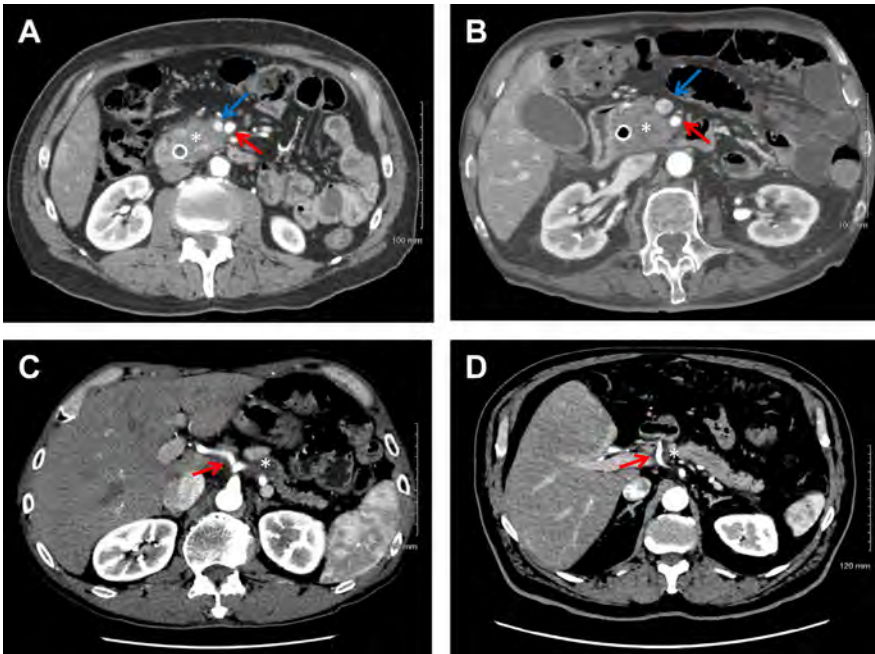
Computed tomography axial images representing borderline resectable pancreas cancer. (A) Narrowing of greater than 50% of the SMV (*blue arrow*). (B) Abutment of the SMA (*red arrow*) of less than 180°. (C) CA (*red arrow*) abutment of less than 180°. (D) Short-segment encasement of the CHA (*red arrow*) amenable to reconstruction. Tumor is marked by *asterisk*.
